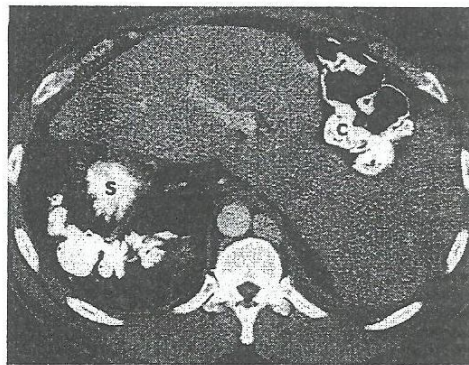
Axial CT image shows Asplenia [Mayr kur 2009]
